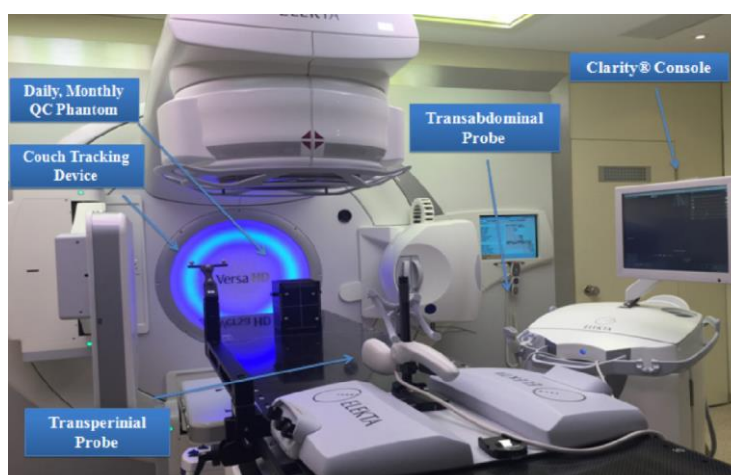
Ultrasound system *Clarity*[®] [60]
